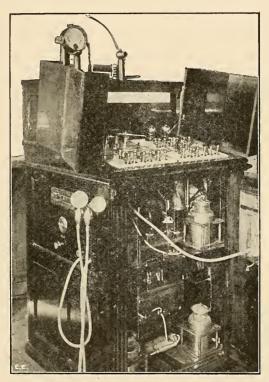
Electrical apparatus of extreme compactness, delivering almost all numbers of electrical modalities, including the new "R-rays" (X-ray, High Frequency, Cautery, Ozone, Vibration, Suction, etc.)
